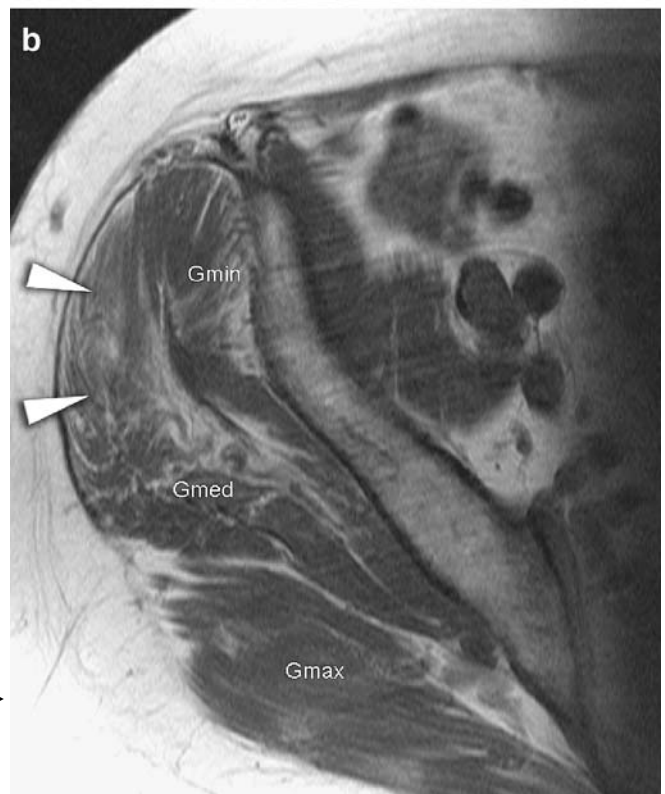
MR imaging findings in a complete tear of the gluteus medius tendon. a The coronal fat-suppressed T2-weighted turbo spin echo image reveals a focal defect superior to the greater trochanter with fluid and edema (arrowheads), representing a complete tear of the gluteus medius tendon. b On the axial T1-weighted spin echo image of the pelvis, fatty degeneration of the anterior portion of the gluteus medius muscle is visible (arrowheads). *Gmin* gluteus minimus muscle, *Gmed* gluteus medius muscle, *Gmax* gluteus maximus muscle
